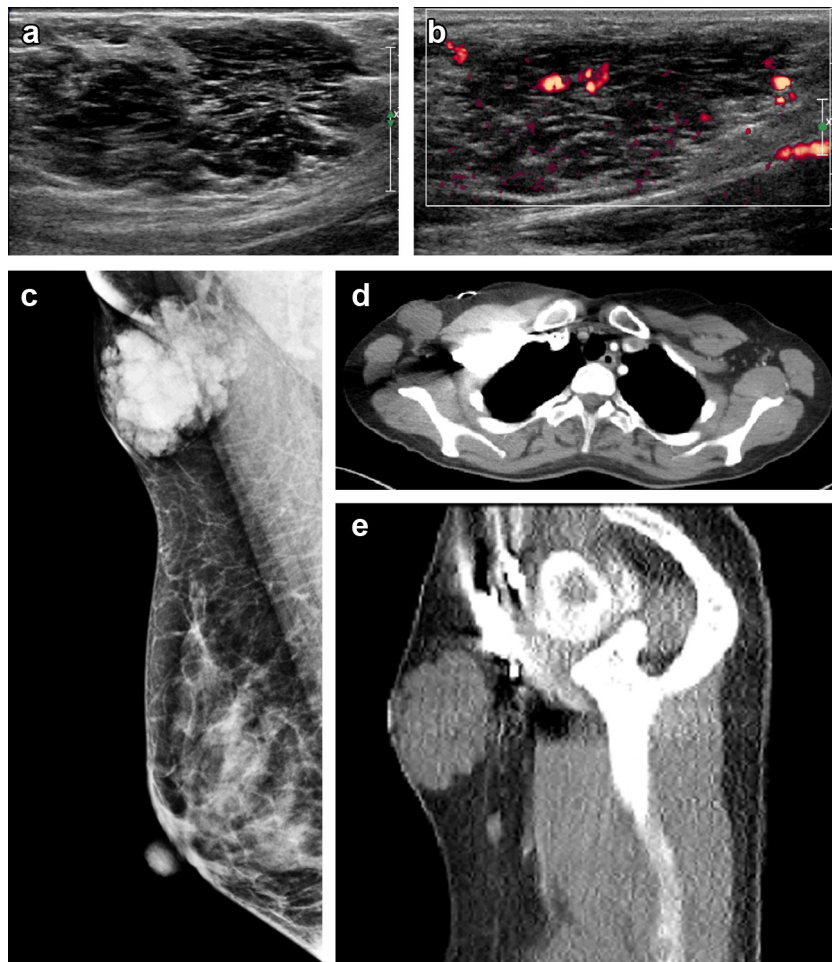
Cavernous hemangioma in a 39-y-old woman. (a, b) Ultrasonography revealed a multi lobulated hypo-echoic mass located underneath the dermis, with heterogeneous parenchymal echotexture and focal hyper-vascularity. The mass consisted of innumerable thin, channel-like structures with mild posterior acoustic enhancement on US. (c) Mammography revealed a multilobulated margined mass with low to high density in the right axilla. (d, e) Enhanced axial and sagittal chest computed tomography images also revealed a multilobulated margined hypo-dense mass with little enhancement in the right axilla.
